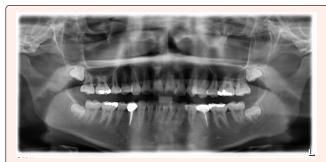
Panoramic radiograph for Follow-up. After five years for mandibular right first premolar and two years and a half years for mandibular left second premolar.
